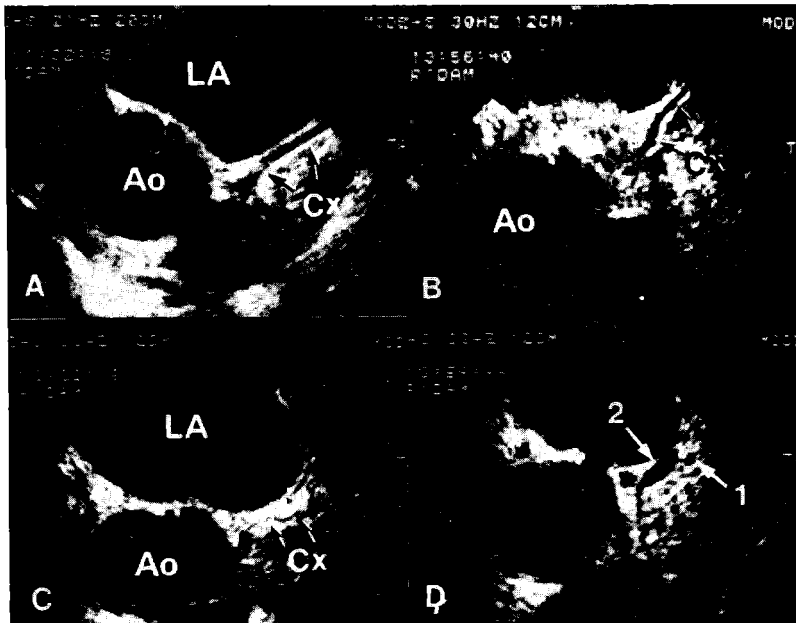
Transesophageal echocardiograms showing the circumflex (CX) artery with a normal (A), a 50-90% stenosis (B), and > 90% stenosis (C). D, Fallacious echoes resulting from the great cardiac vein (arrow 2) may mimic a patent circumflex artery (arrow 1). LA = left atrium; Ao = aorta; CX = left circumflex artery.
